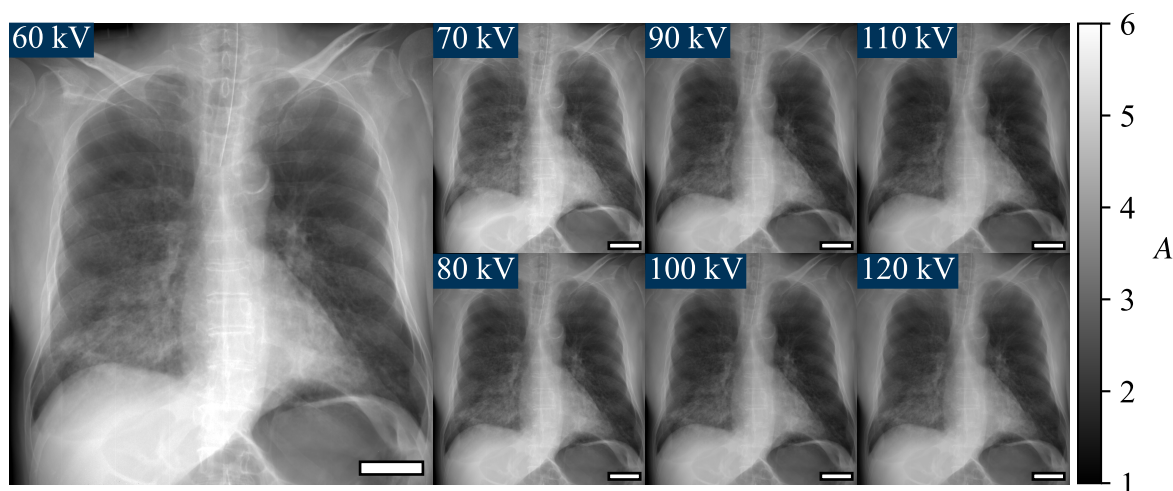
Attenuation radiographs of a human thorax at the examined tube voltages. All images are shown with the same windowing. The scale bar in the lower right corner has the size 5 cm × 1 cm. Signal strength and image quality barely changes for different tube voltages.
